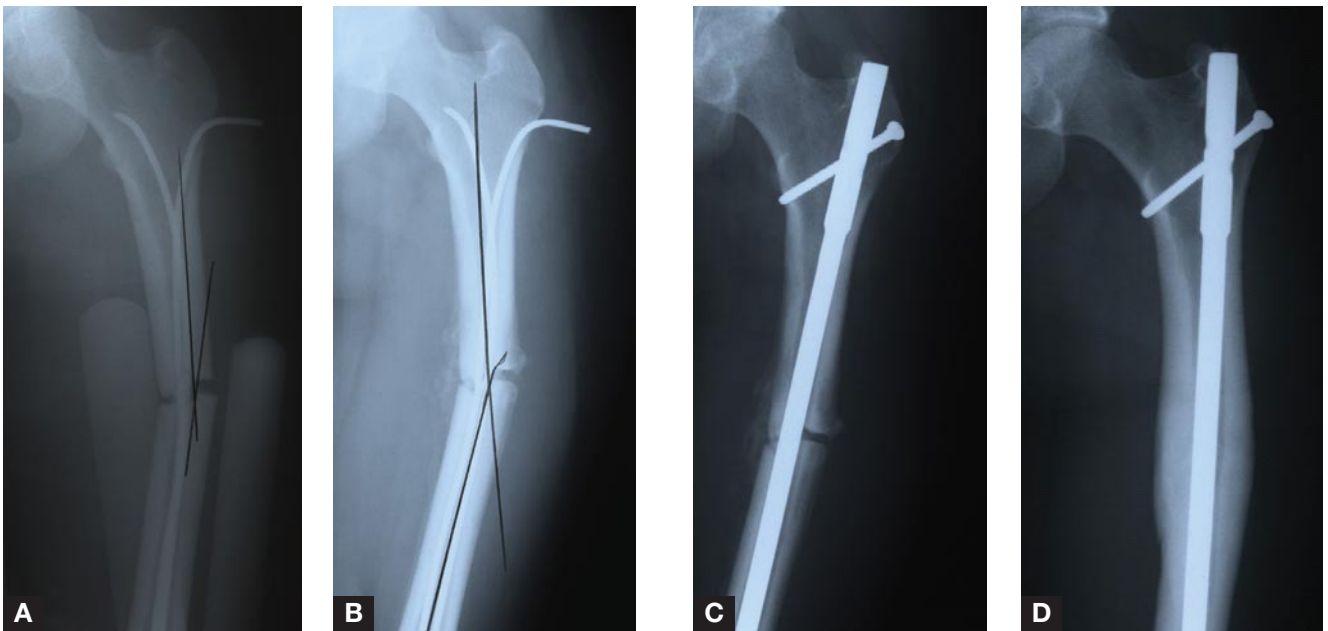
A 14-year-old girl sustained a midshaft transverse femoral shaft fracture in a motor vehicle accident. Despite stabilization with titanium elastic nails, the fracture did not unite; after the nails were replaced with a rigid intramedullary nail, the fracture healed without incident. (A) Radiograph 4 weeks after stabilization. (B) Radiograph a few months after surgery (4-mm gap at fracture site and some varus angulation remain). (C) Initial radiograph after nail exchange. (D) Radiograph shows complete fracture healing.
